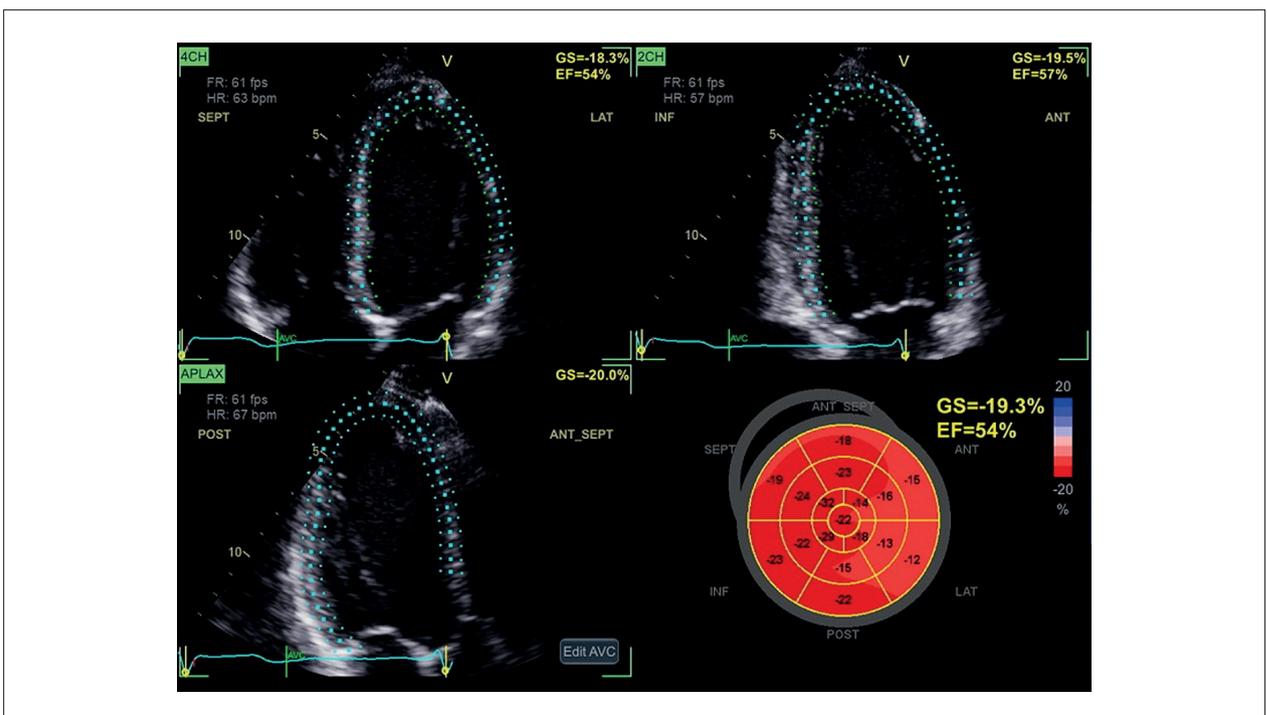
Apical four-, two-, and three-chamber views showing left ventricular longitudinal strain analysis derived from speckle tracking.
